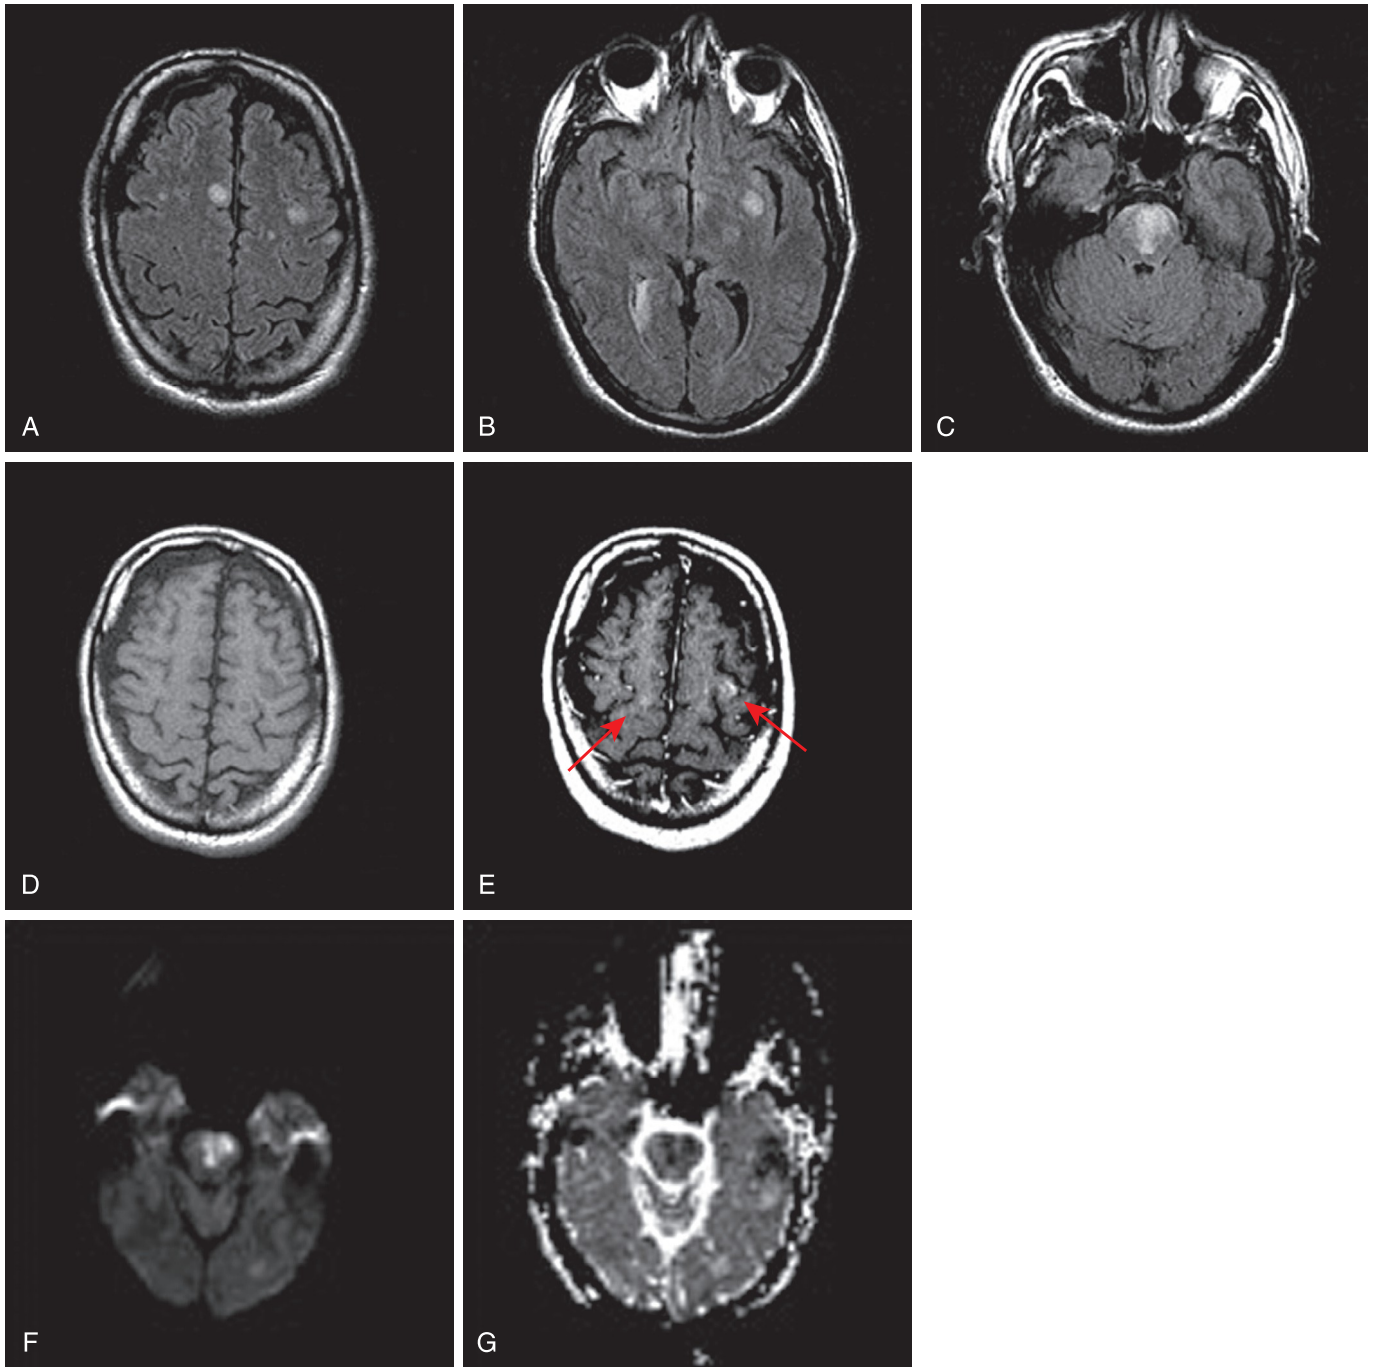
Intravascular lymphoma case example. A 50-year-old male with biopsy-proven intravascular lymphoma. Axial FLAIR images (A–C), axial T1 precontrast (D), axial T1 postcontrast (E), DWI (F), and ADC (G) images demonstrate multifocal white matter lesions involving both cerebral hemispheres and pons; some lesions have associated enhancement (arrows) and restricted diffusion (pontine lesions).
